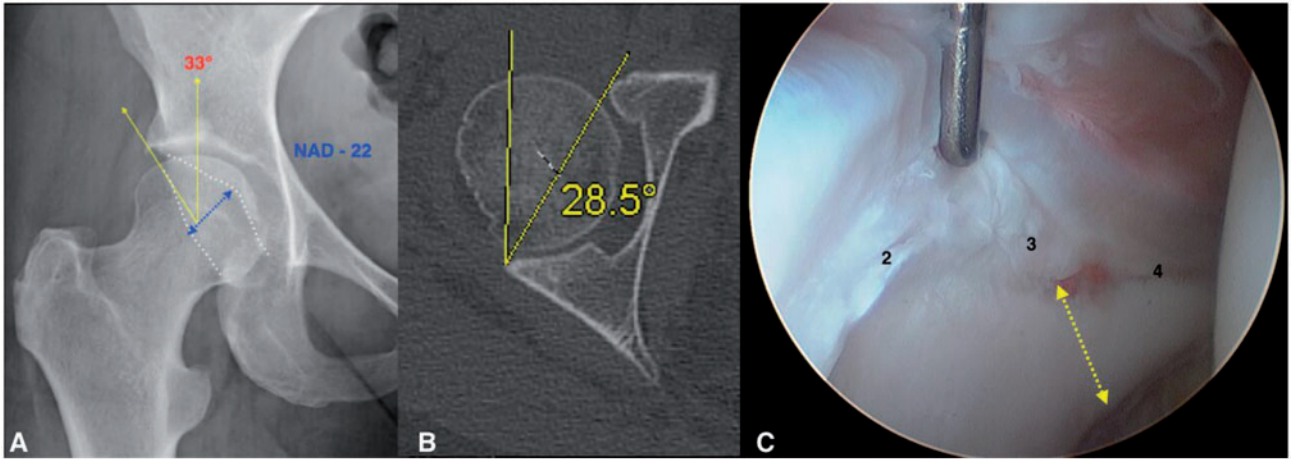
(A) This AP pelvic radiograph of a patient with NAD = 22 mm (blue line) indicates excessive acetabular anteversion. Note the lateral instability sign in the form of a traction osteophyte, although the lateral center edge angle is normal (33 degrees). (B) A CT of the same patient with CT equatorial acetabular version angle of 28.5° confirms excessive acetabular version. (C) An arthroscopic view of the same patient shows an anterior displaced labral tear with very short distance from the acetabular rim to the acetabular fossa (yellow arrow). The hours of the clock are noted. This patient went on to have corrective osteotomy in the form of a periacetabular osteotomy.
